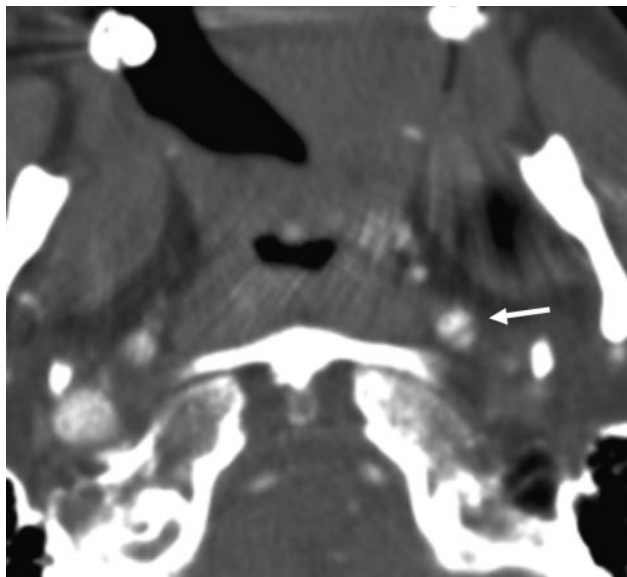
Axial source image of the CTA of a patient without clinical signs or symptoms of severe head or neck injury. Dissection of the left internal carotid artery (intima flap indicated by white arrow) with patency of both lumens.
